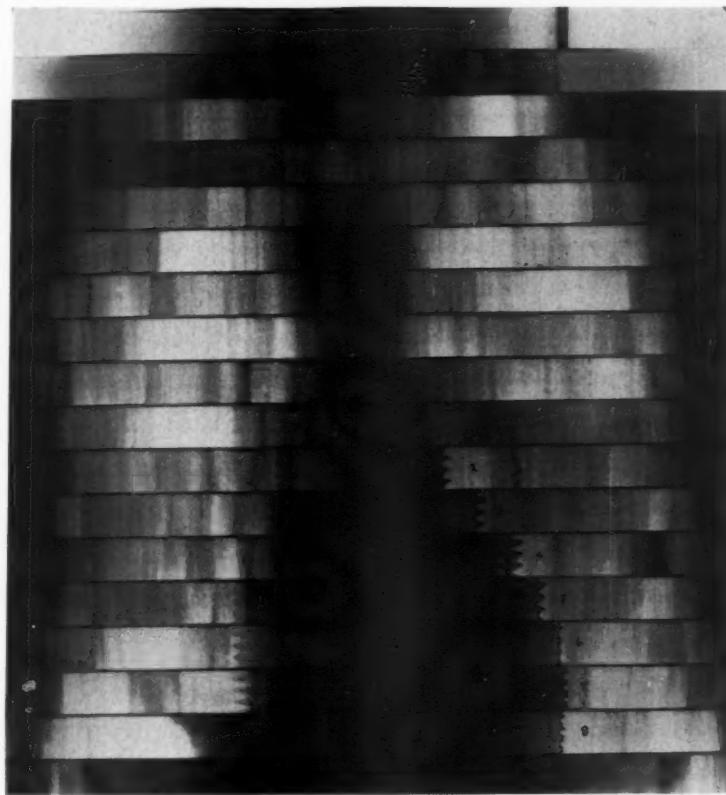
Posteroanterior roentgenkymogram from a man 37 years old. Coronary artery occlusion four months previously. Diminution in pulsation seen in interval six, and systolic expansion in intervals seven and eight.
